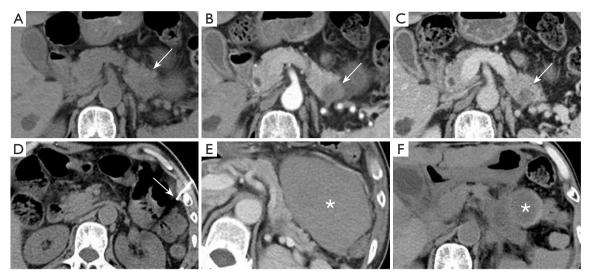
A 68-year-old male individual underwent CT-guided percutaneous core needle biopsy for pancreatic lesion. (A) On non-contrast CT, a low-density lesion shows in the pancreatic body and tail (arrow indicates the lesion). (B,C) The lesion exhibited unclear boundaries and an irregular shape. Post-contrast imaging revealed hypo-enhancement of the lesion (arrow indicates the lesion). (D) A core needle biopsy of the pancreatic lesion was performed under CT guidance (arrow indicates the puncture needle). (E) On the second day post-procedure, an abdominal CT scan revealed a mixed, slightly high-density mass measuring approximately 10.6 cm × 7.8 cm in the left upper abdomen, without enhancement, suggesting a possible hematoma (* indicates the bleeding site). Hemostasis was managed with carbazochrome sodium sulfonate and batroxobin. (F) A follow-up CT scan 4 weeks later showed a reduction in the size of the hematoma to approximately 2.4 cm × 1.8 cm (* indicates the bleeding site). CT, computed tomography.
